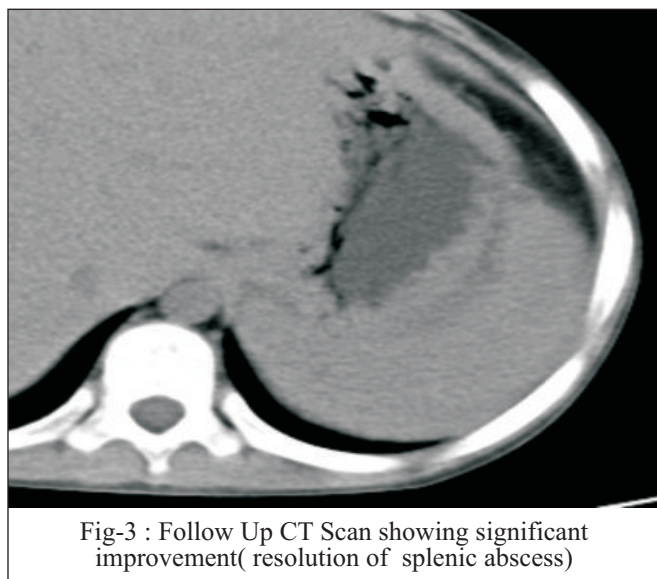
Follow Up CT Scan showing significant improvement(resolution of splenic abscess)
